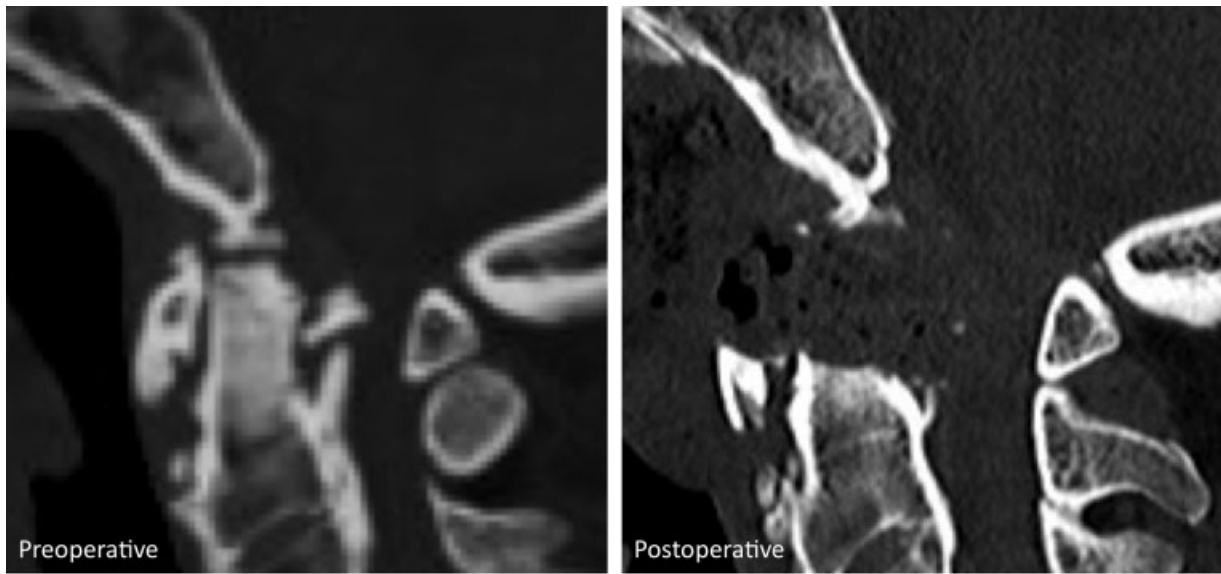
Pre- and postoperative sagittal CT.
